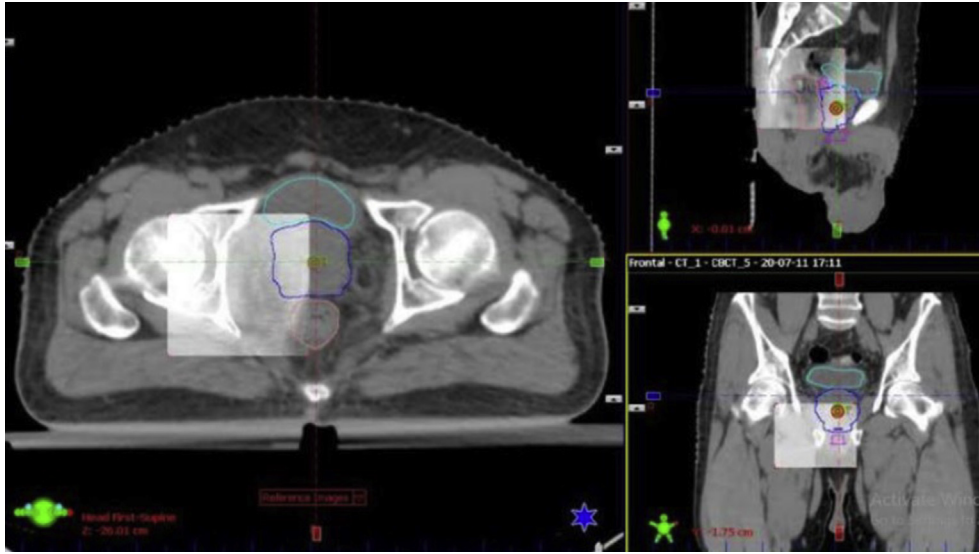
Prostate to prostate matching by superimposing the cone-beam computed tomography (CBCT) and CT images by spyglass method.
